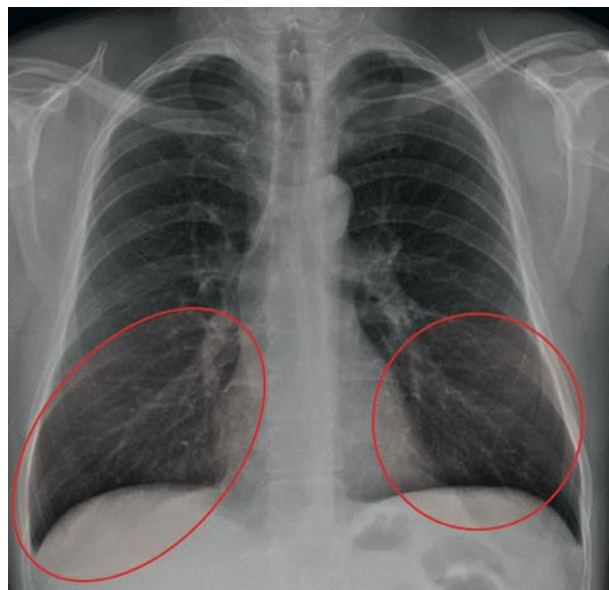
Millimetric nodule image on the patient’s posteroanterior chest X-ray (red areas)
